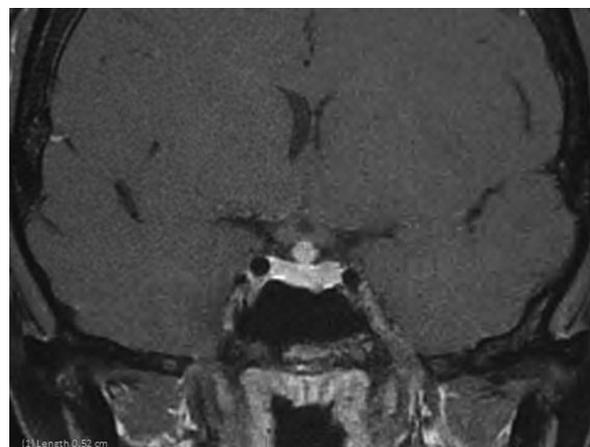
MRI pituitary: T1W coronal with contrast - thickened pituitary stalk and enhancement. MRI = magnetic resonance imaging.
